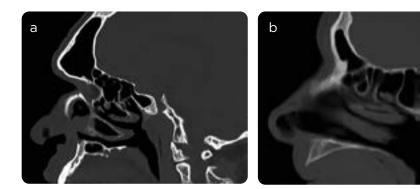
a) Sagittal bone window scintigraphy reconstruction: the increase in the diameter of the frontal sinus by hyperpneumatization is observed in a patient with acromegaly. b) Sagittal bone window scintigraphy reconstruction, in a patient without acromegaly: note the difference in the size of the frontal sinus in comparison with image a).
